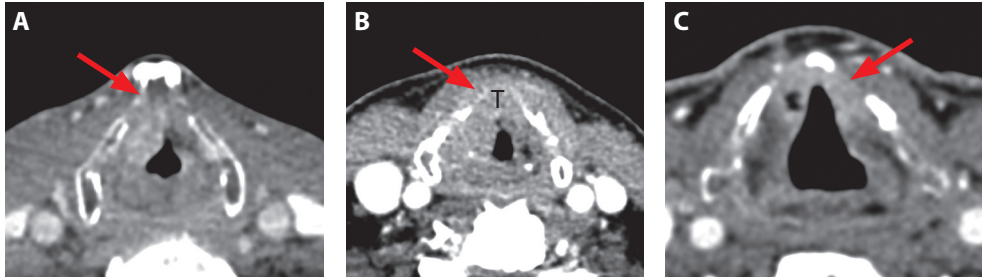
Positive criteria of non-ossified cartilage invasion (red arrow) on contrast-enhanced CT*
